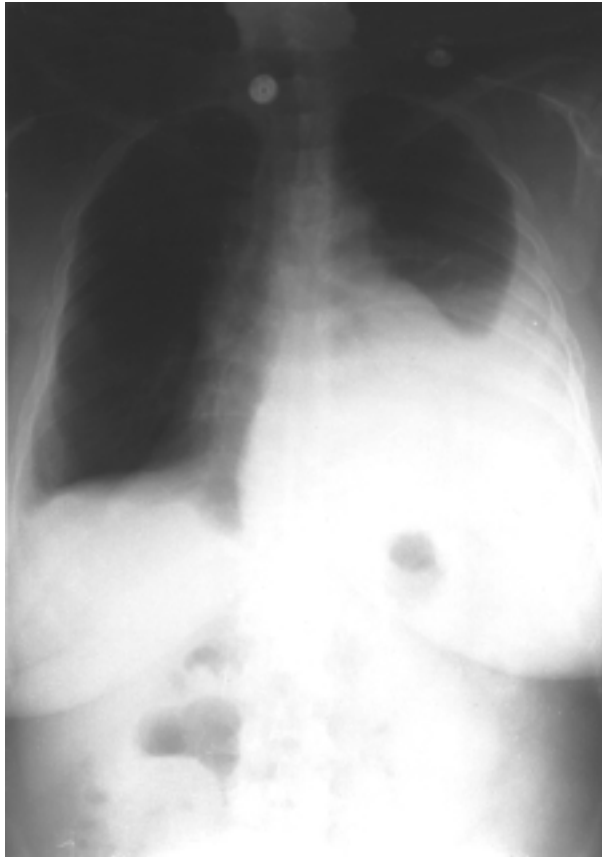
Chest radiography of the patient with left pleural effusion 7 years after presentation with right pleural effusion.
